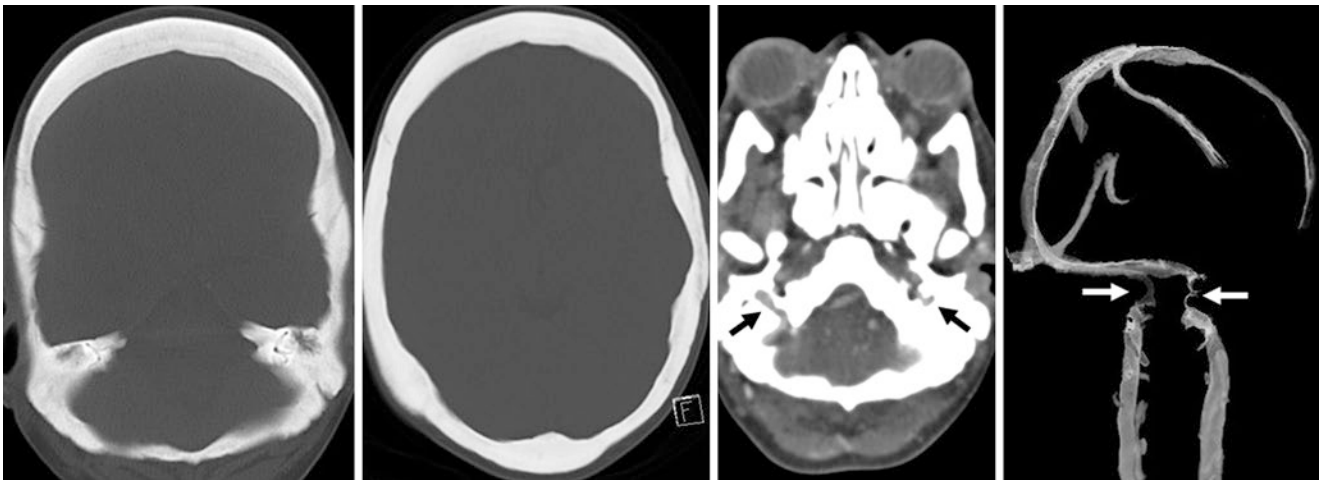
Comparison case of osteopetrosis: In a 17-year-old female a diffusely thickened and hyperdense skull was noted on axial NECT (left images). A CT venogram (right middle) showed diminutive jugular
